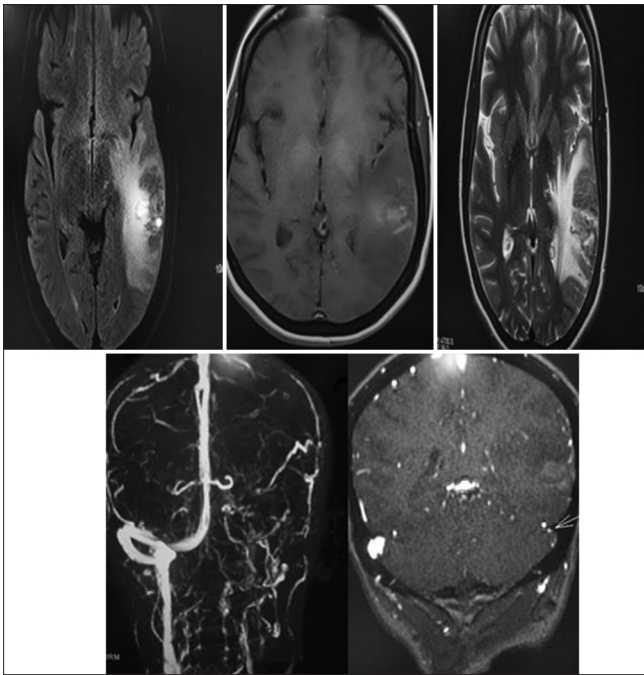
There is evidence of T2/FLAIR heterogenous hyperintense area in the left parietal region with areas of T1 hyperintensity corresponding to hemorrhage. Magnetic resonance venogram showing nonvisualization of left transverse, sigmoid sinus, and internal jugular vein with filling defect (arrow)
